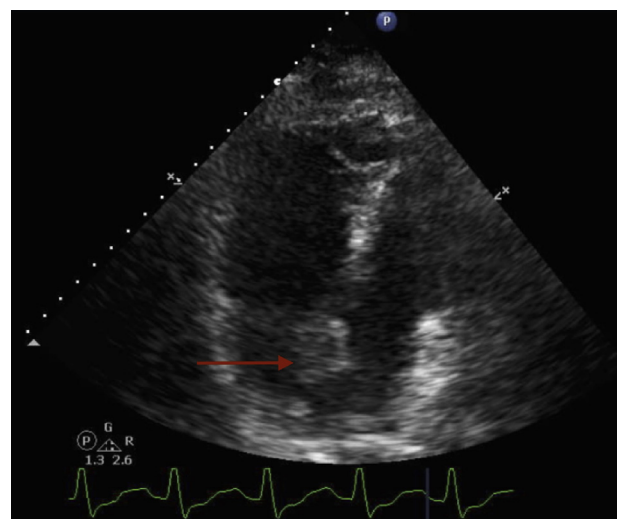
Sonogram of the heart (apical view) outlining significant right ventricular strain and thrombus in right atrium (arrow).
